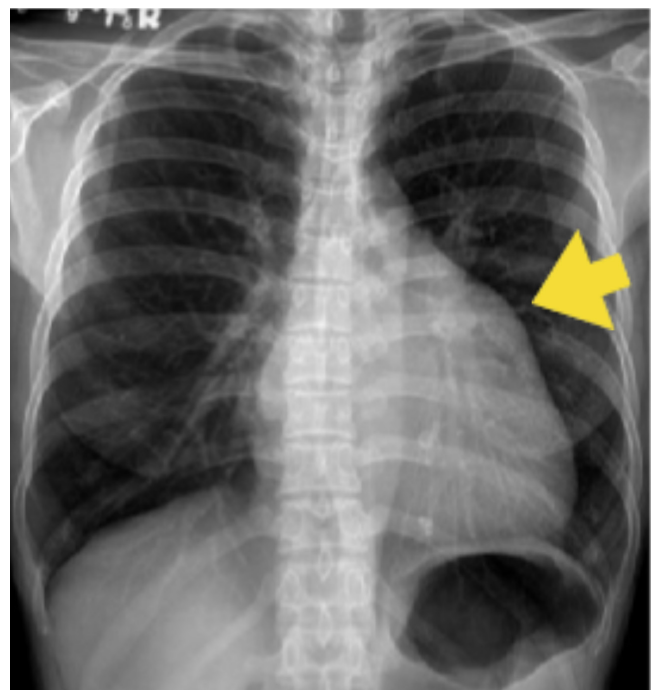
The chest radiograph. This was taken in a postero-anterior projection showing that the pulmonary vascular markings are prominent with the heart that is enlarged with left ventricular prominence and bulging of the left atrial appendage (yellow arrow). The cardiothoracic ratio is 0.54.
